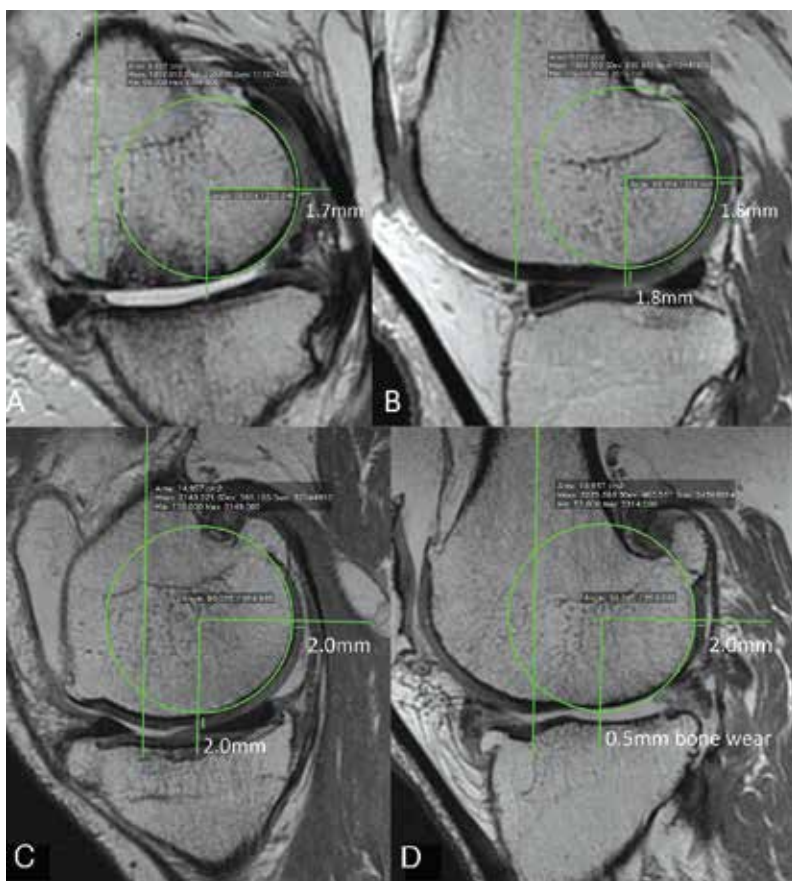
Magnetic resonance images show the typical medial hemijoint (A) and lateral hemijoint (B) in the varus osteoarthritic knee, and the typical medial hemijoint (C) and lateral hemijoint (D) of the valgus osteoarthritic knee. In the varus osteoarthritic knee, cartilage wear is confined to the distal medial condyle. In the valgus osteoarthritic knee, cartilage wear is confined to the distal lateral condyle. Cartilage wear to bone averages 1.9 mm [15].
